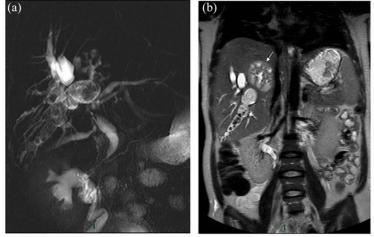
A 30-year-old Vietnamese woman with acute cholangitis, septicaemia, and shock. MRCP (A) shows a major dilatation of the right posterior intrahepatic bile duct filled with large stones and lithogenic material. Coronal MR T2-weighted image (B) shows a multilocular abscess of segment VII of the liver (arrow). Diagnosis was recurrent pyogenic cholangitis (oriental cholangitis) [1].
